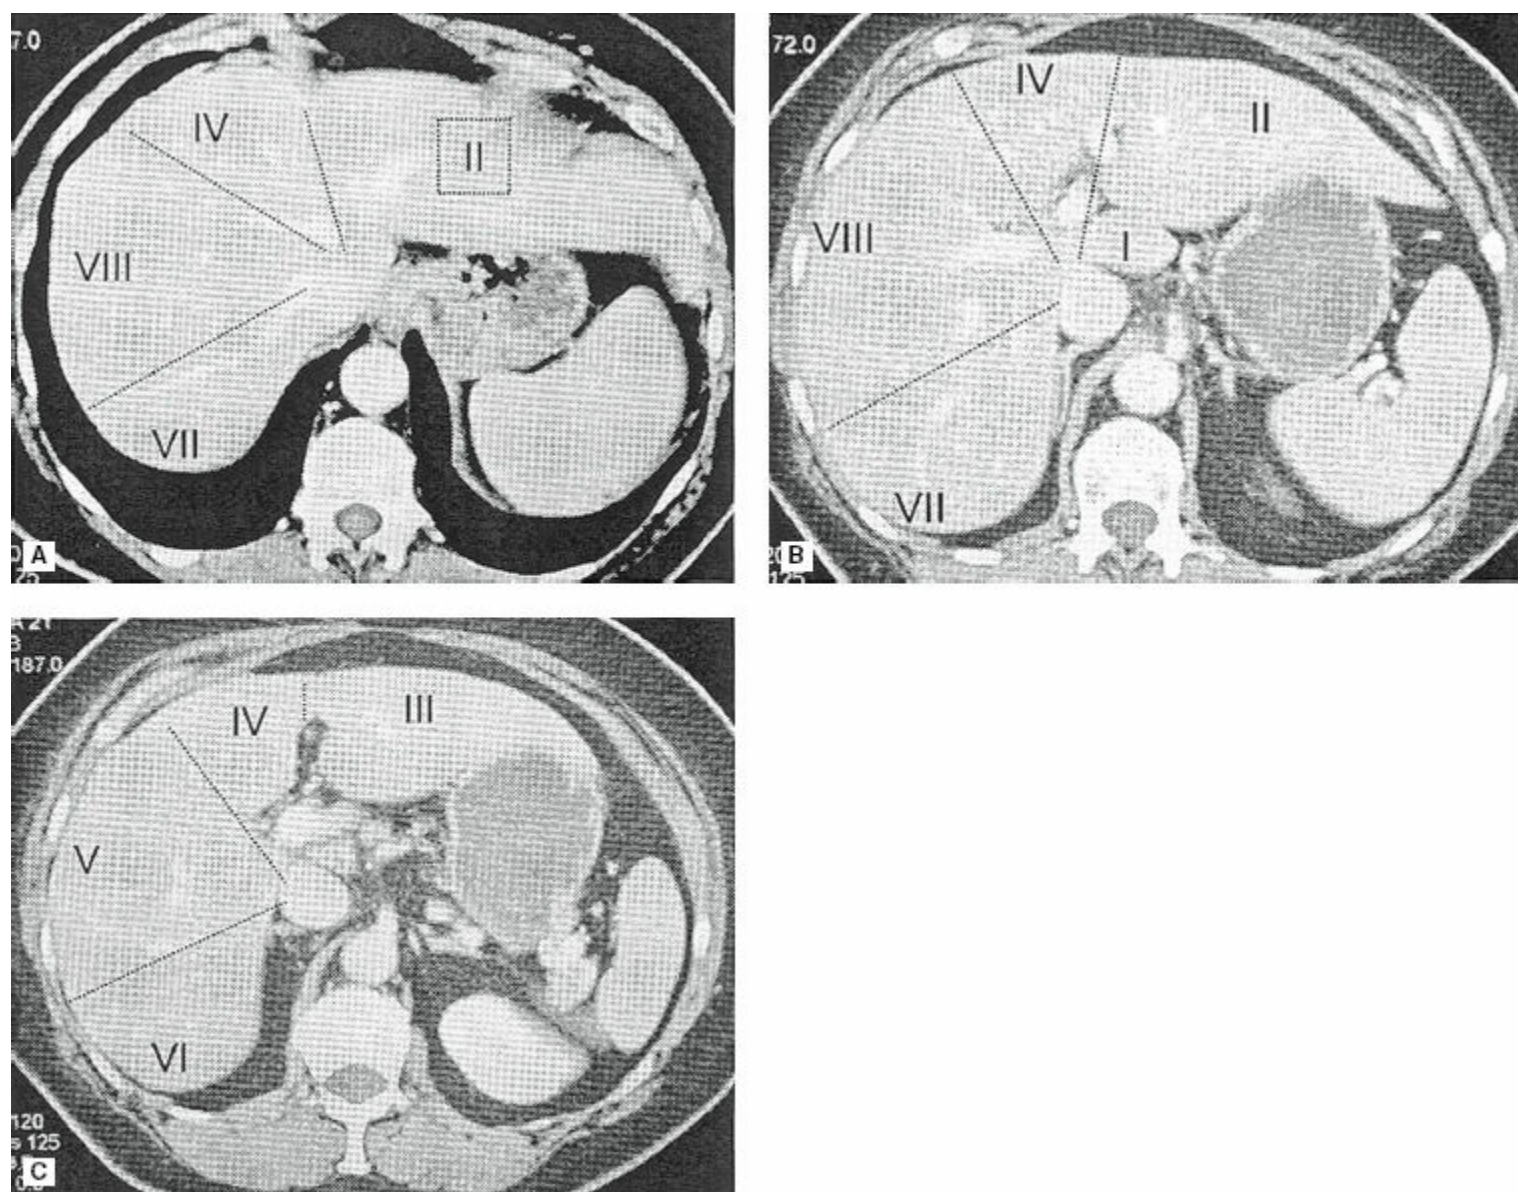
Computed tomography scan demonstrating segmental anatomy of the liver with cuts through the dome (A), just above the portal bifurcation (B), and below the portal bifurcation (C).
